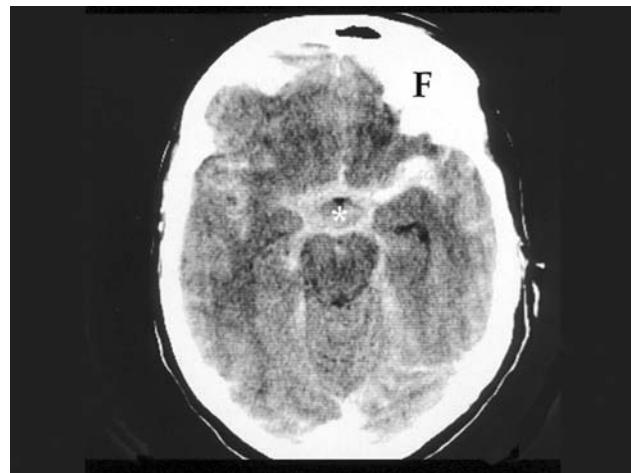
(A) A CT scan of a subarachnoid hemorrhage. On CT, a subarachnoid hemorrhage is best imaged by looking at a plane of section through the midbrain. At this level, the subarachnoid space has a five-pointed star-like shape as it surrounds the pituitary stalk (asterisk) and midbrain. If blood is present, the CT will reveal a bright subarachnoid space. F, orbital plate of frontal bone. (B) An MRI scan through a normal brain at nearly the same plane of section seen in (A). Note how the subarachnoid space around the midbrain (M) and pituitary stalk (P) is dark. In a CT scan, if the subarachnoid space is filled with blood, the signal is bright (see A).
